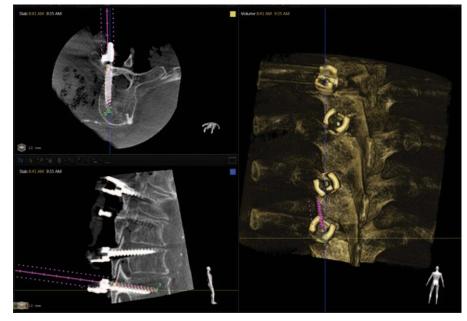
Examples of 3D CBCT acquired postoperatively. Note the complete absence of streaking (*i.e.*, beam hardening) artifact despite the presence of four screws, as the CBCT was performed at $+20^{\circ}$ angulation of the C-arm.
